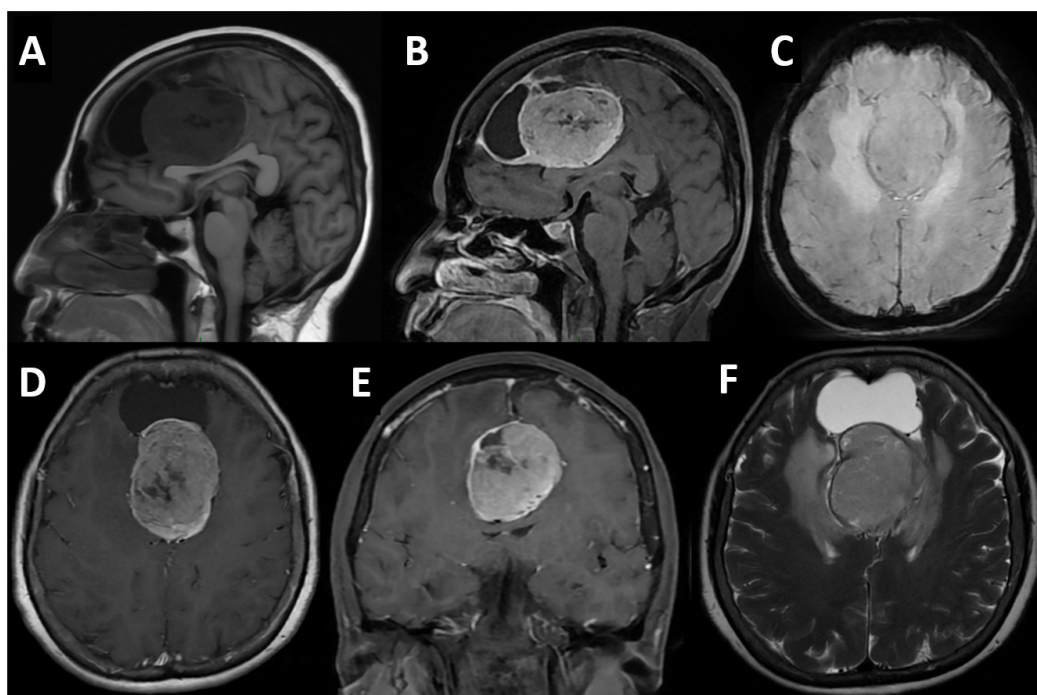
Non-contrasted MRI T1 sequence in sagittal view (A) shows the lesion causing ventral and caudal displacement of the surrounding structures. Post-contrast sagittal, axial, and coronal sequences (B, D, and E, respectively) showing intense and heterogeneous enhancement of the solid component and dural enhancement. Axial SWI sequence (C) with hypointense foci related to hemosiderin deposits. Axial T2 sequence (F) enlightens the cystic component as isointense to fluid and vasogenic edema of the white matter.
